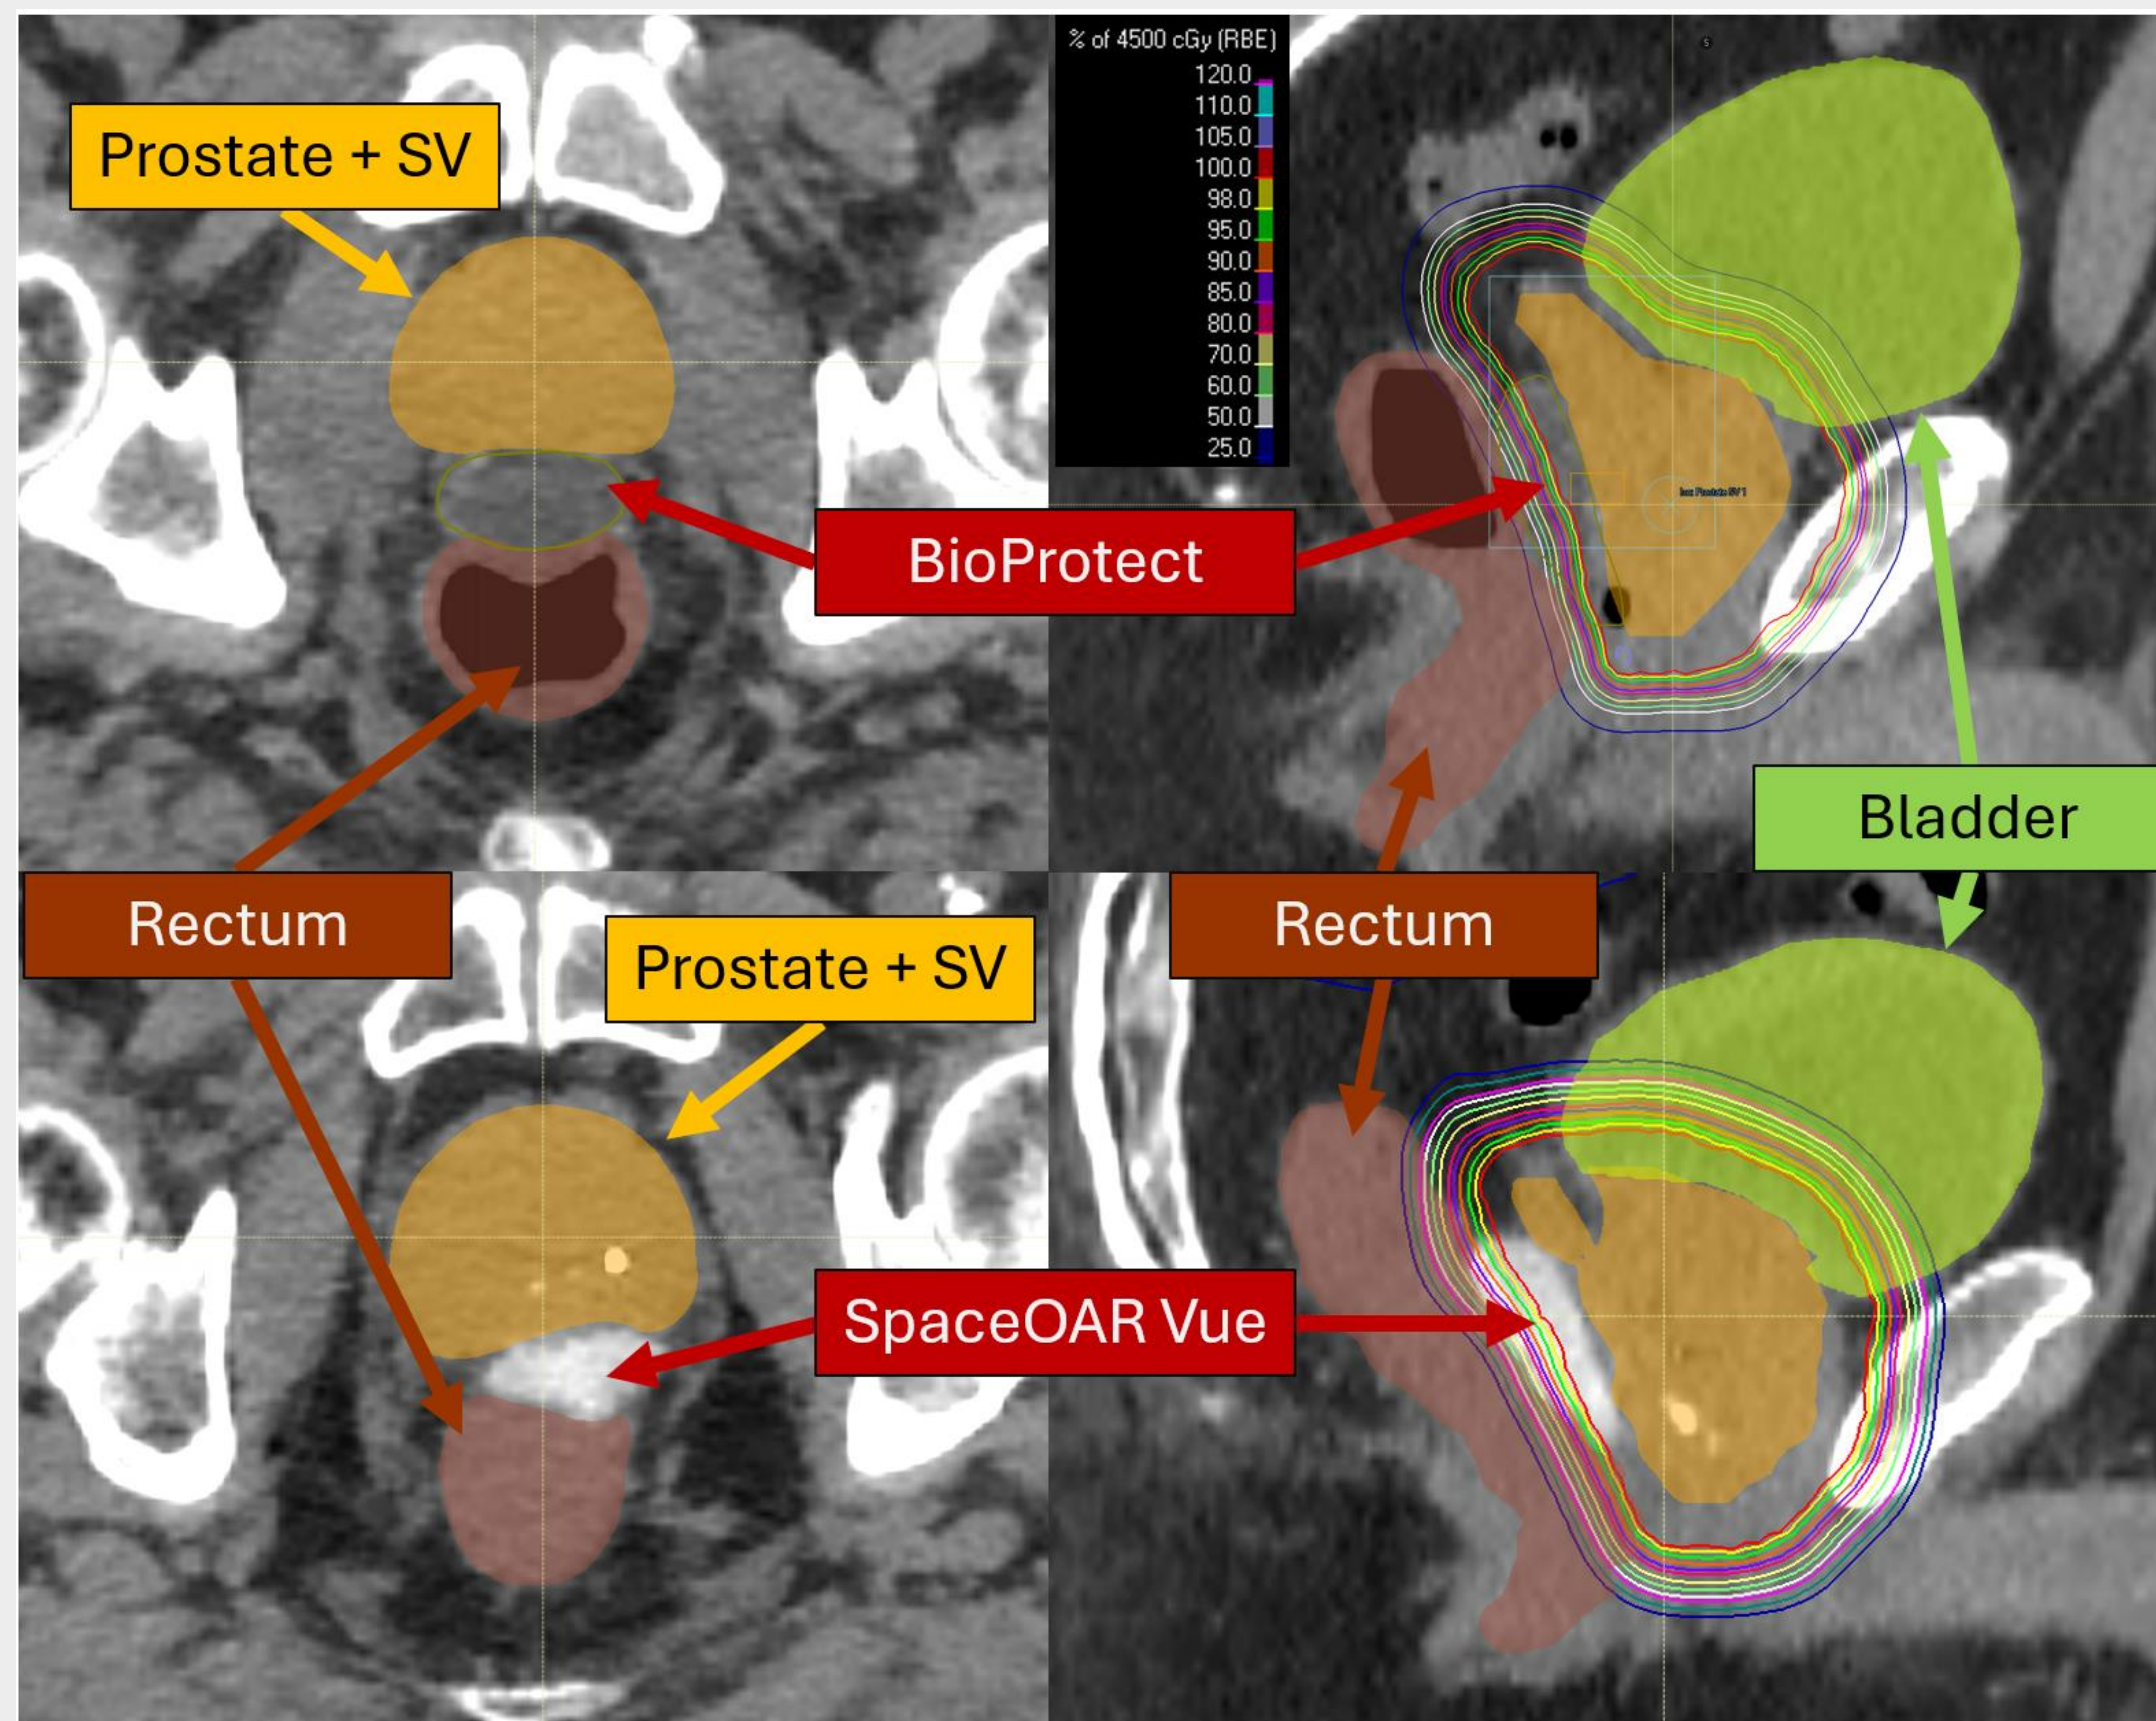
CT scan of representative patients with implanted BioProtect (top) and SpaceOAR Vue (bottom) spacers. Axial views (left) show anatomical separation, while sagittal views (right) show dose distributions.
